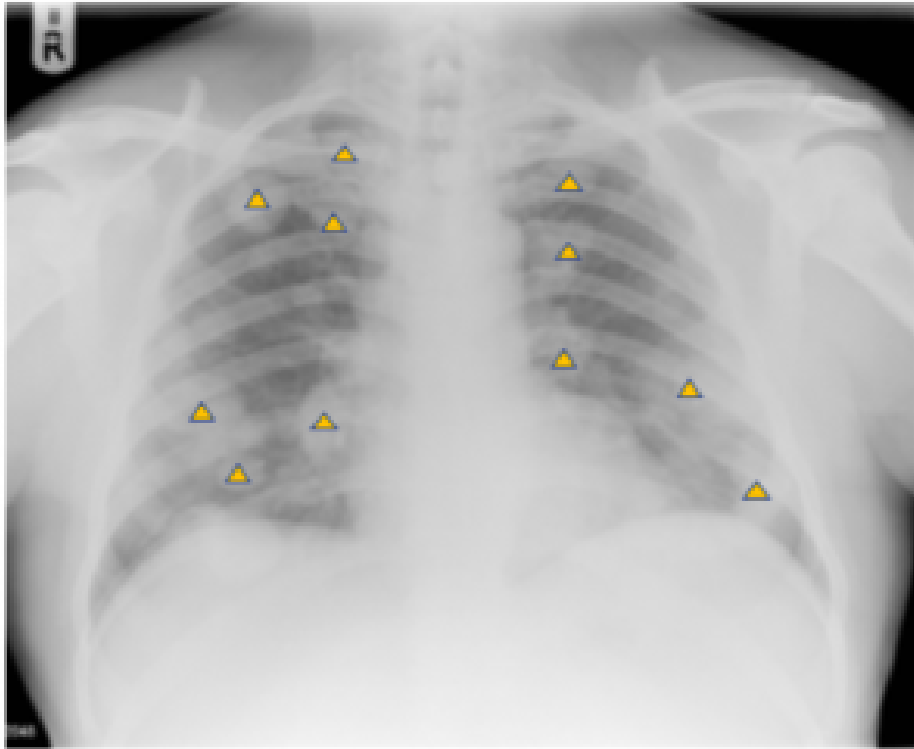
Chest X-Ray shows multiple lung lesions aligned with metastatic deposits (yellow arrows).¹
